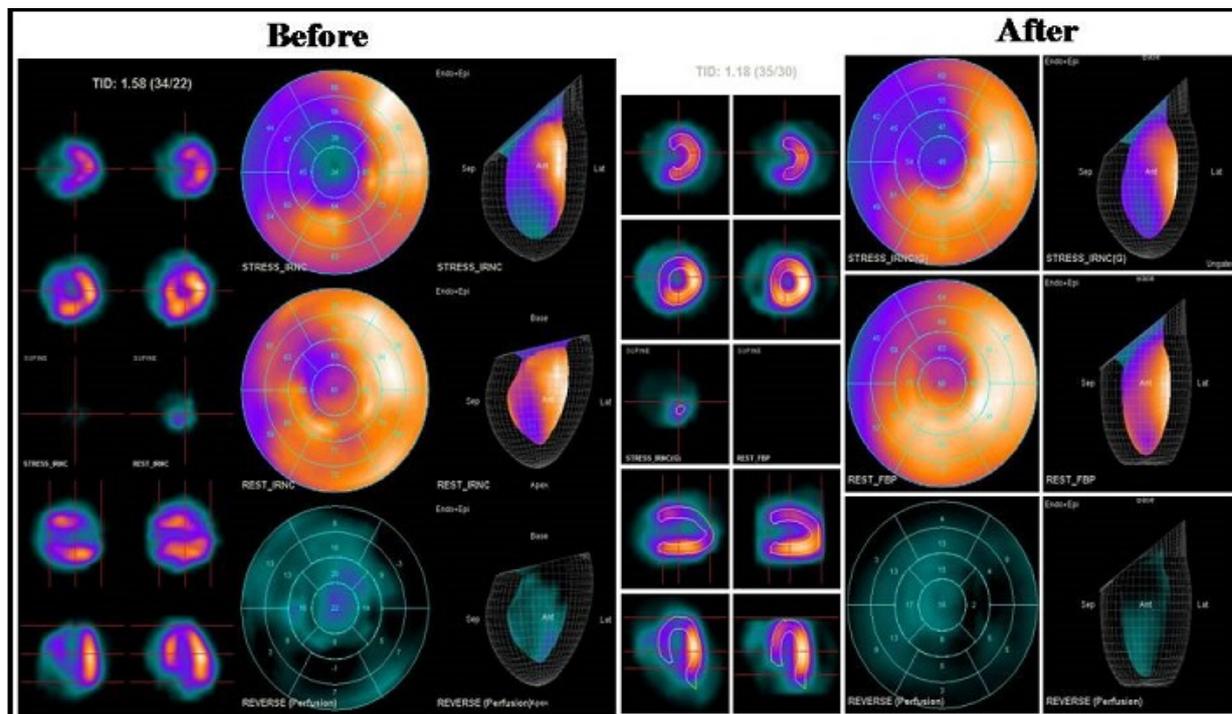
Depicts one of the SPECT-MPI images showing improvement in myocardial perfusion after 21 IRP sittings as compared to baseline.
